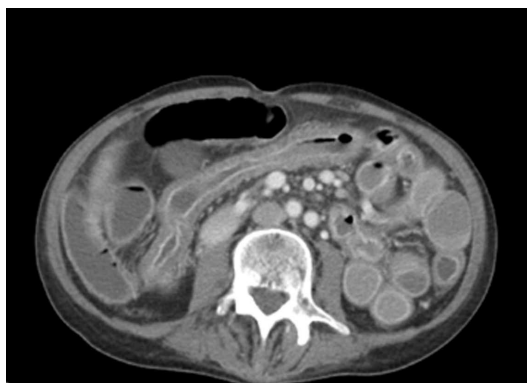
Initial computed tomography of abdomen showing diffuse mural thickening of the small and large bowel. Approximately 2 wk following cyclophosphamide treatment.
